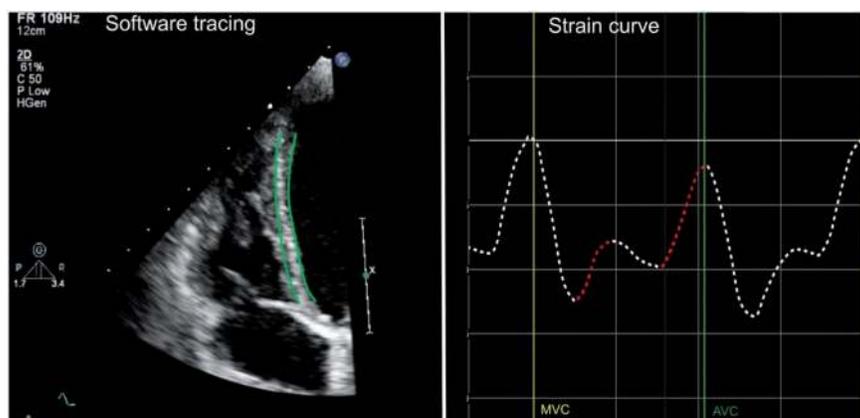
Septal single wall image acquisition of systolic rebound stretch of the septum (SRSsept)-in red-defined as septal stretching after initial shortening. Speckle tracking echocardiography software was used to deduce strain curves of the focused LV septal wall image. MVC, mitral valve closing; AVC, aortic valve closing [65].
